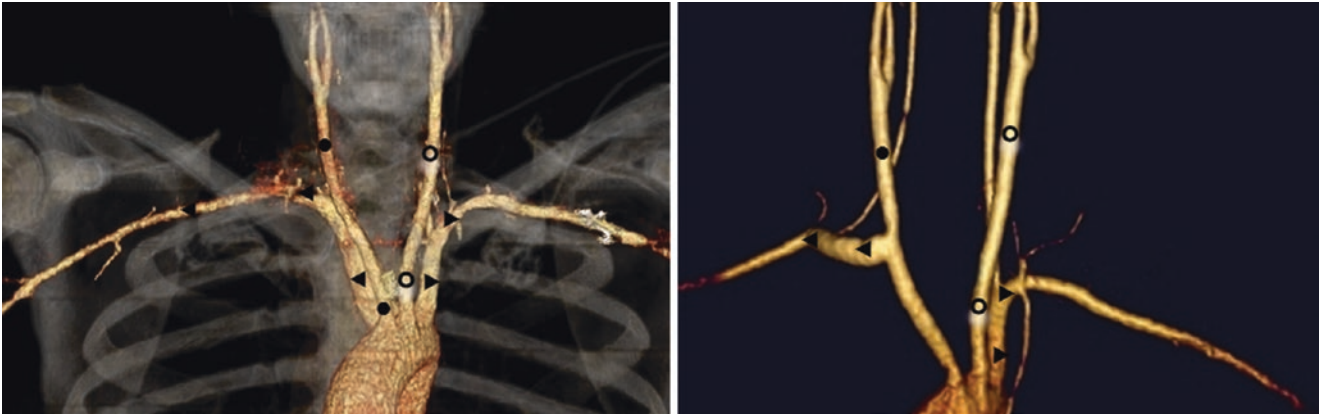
43-year-old with a left arch and a retroesophageal RSCA (left-facing arrowheads) on an AP view from a CTA (left). Two weeks after the RSCA was detached and reimplanted to the right common carotid artery (RCCA, black circle), there was no stenosis at the vessel's
